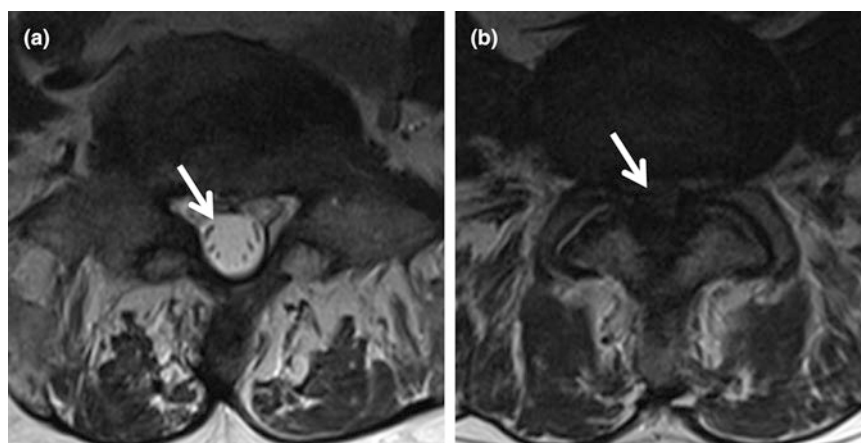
MRI (T2) axial images at the level of the lower lumbar spine. a The normal spinal canal with the thecal sac containing the cauda equina (arrow). b In this patient with cauda equina syndrome there is disc herniation narrowing of the spinal canal and compression of the cauda equina nerve roots
